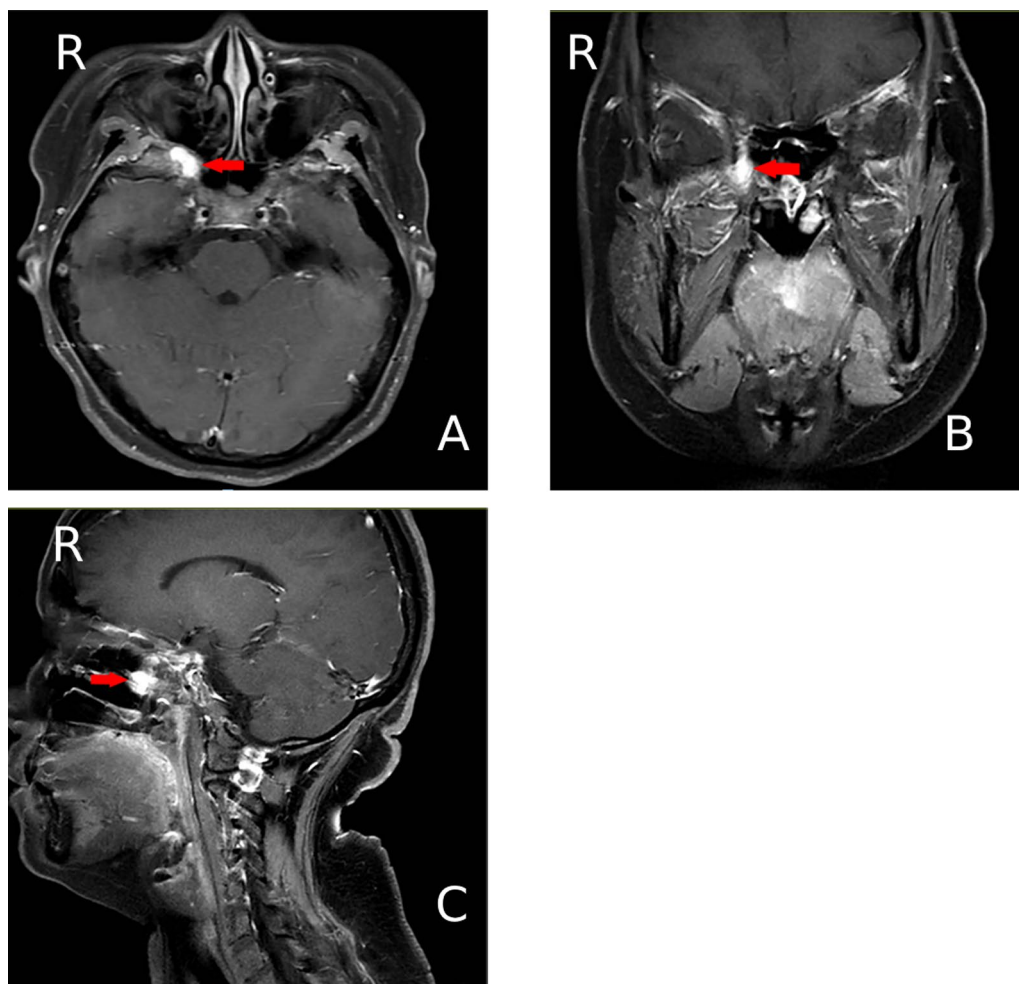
Magnetic resonance imaging with and without contrast enhancement showing a round area of abnormal signal (as indicated by arrow) in the right pterygopalatine fossa, measuring approximately 14 mm × 7 mm (The arrows point to the tumor)
